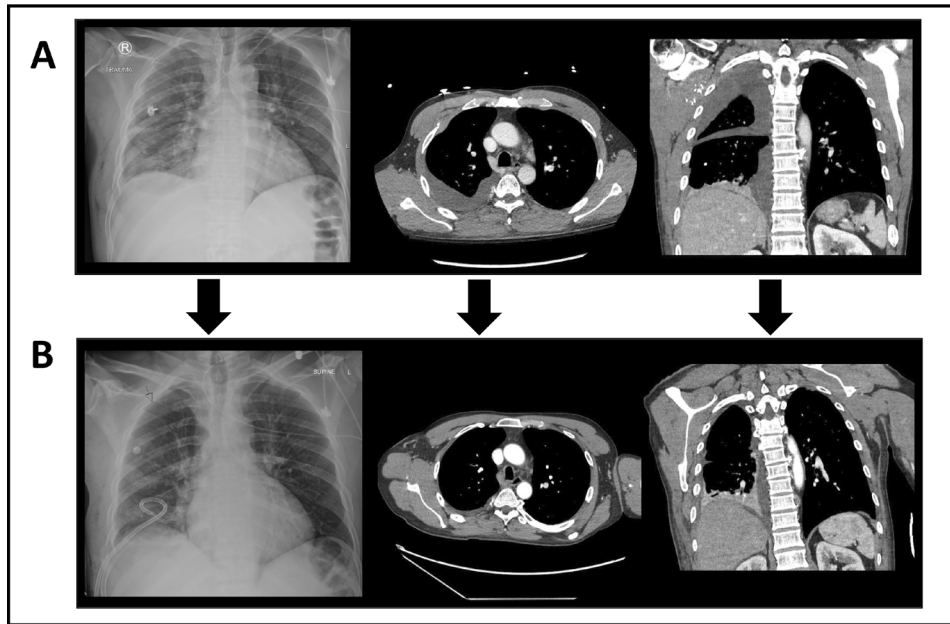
Interval improvement in hemothorax immediately after percutaneous thoracostomy with lavage (case 9). (A) Pre-CT chest X-ray (CXR) and CT chest at admission. (B) CXR demonstrating catheter placement and CT chest after catheter removal.
